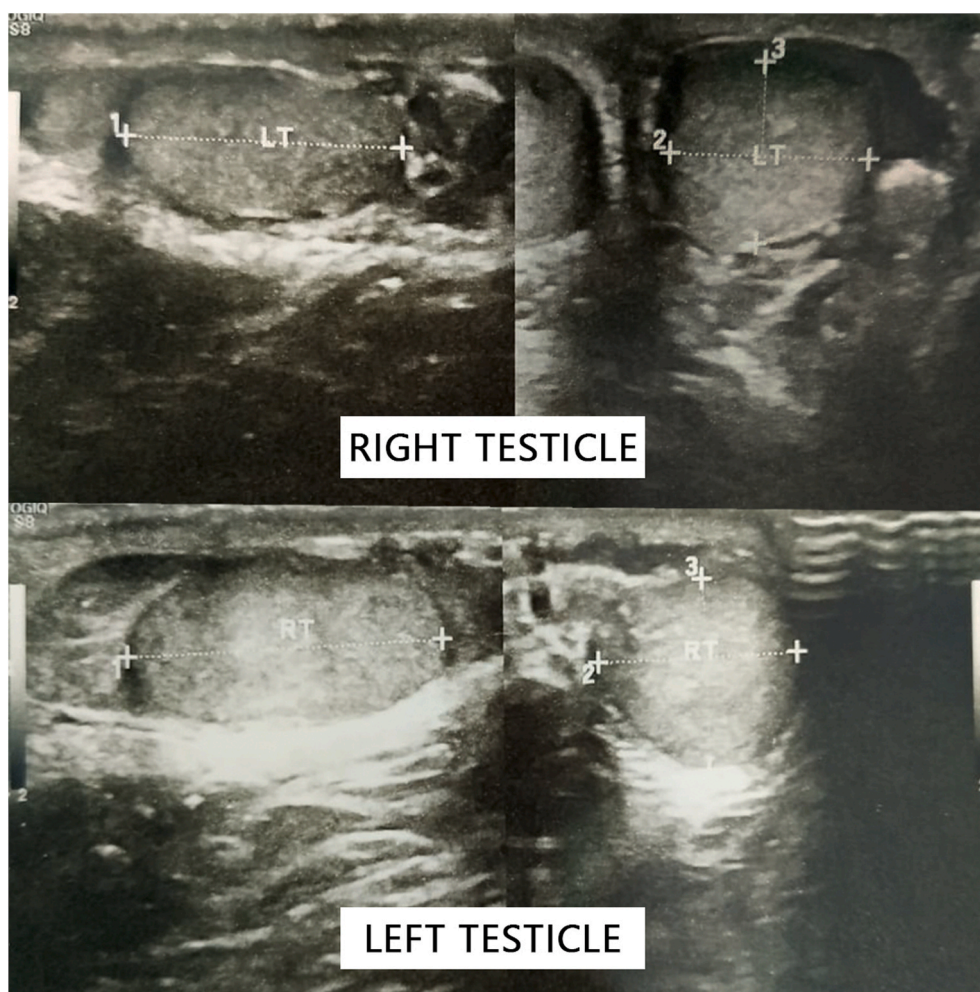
Ultrasound examination of right and left testicles.
